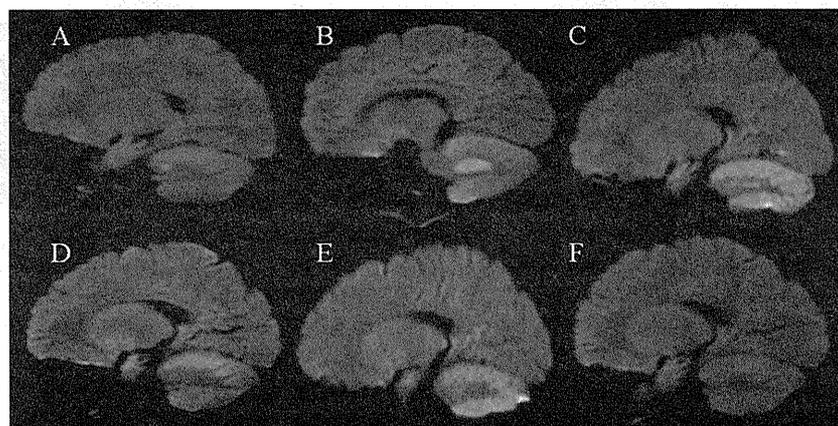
Chronological cerebellar DWI findings in case 3. (A) Sagittal DWI on day 1 showed small spotty hyperintensity lesions near the dentate nucleus. (B) Sagittal DWI on day 3 showed marked hyperintensity in the bilateral dentate nucleus and the vermis. (C) Sagittal DWI on day 5 showed decreased hyperintensity in the vermis and increased intensity in cerebellar hemisphere. (D) Sagittal DWI on day 9 showed ceased hyperintensity in the vermis and increased intensity in cerebellar hemisphere. (E) Sagittal DWI on day 18 showed almost the same findings as those on day 9. The hyperintensity in lower part of cerebellar hemisphere was greater. (F) Sagittal DWI on day 25 showed decreased hyperintensity in cerebellar hemisphere.
